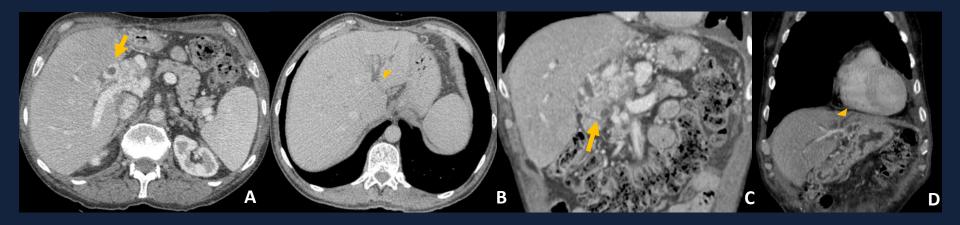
62-year old male patient with portal cavernoma. (A) and (B) Axial contrast-enhanced CT images showing portal cavernoma (arrow) surrounding the common bile duct with consequente intra-hepatic bile ducts dillatation, especially the branches of the left hepatic lobe (arrowhead). (C) and (D) Coronal contrast-enhanced CT images confirming the existence of portal cavernomatous transformation (arrow) with upstream dilatation (arrowhead).
